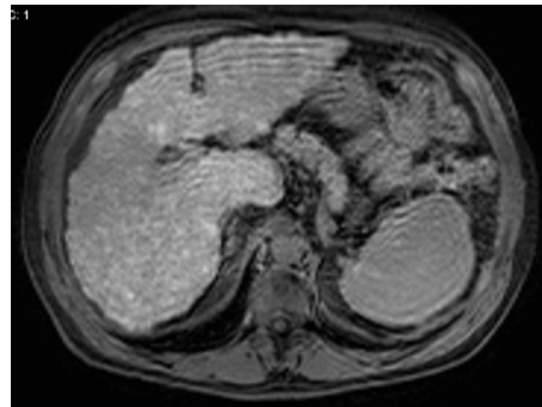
Dysplastic nodule – MRI - T1 SPAIR (fat suppression) Axial contrast-enhanced hepatobiliary phase. It is not clear any change in the topography previously described
